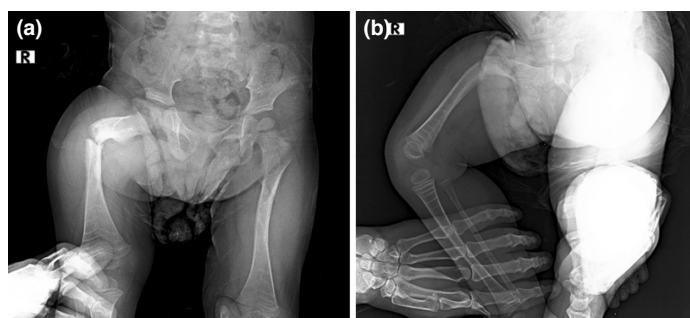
X-ray images of the patient 2 years ago after arrival to hospital (a) Right femur ap view. (b) Right femur lateral view.
